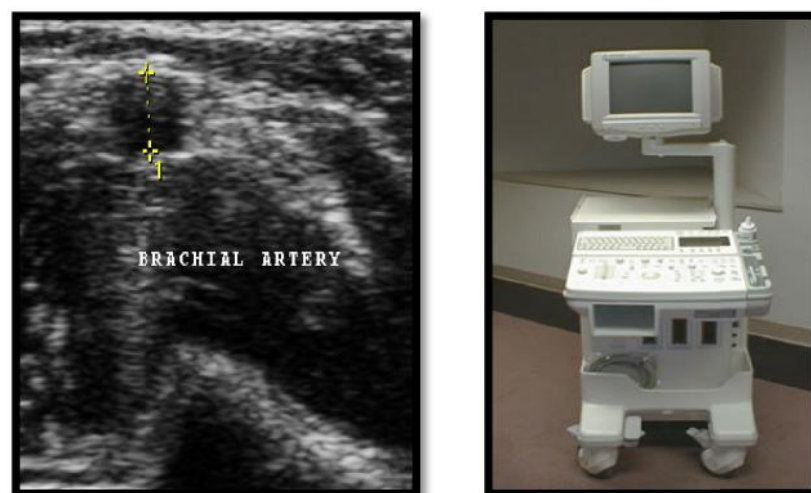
Usgcolour Doppler
